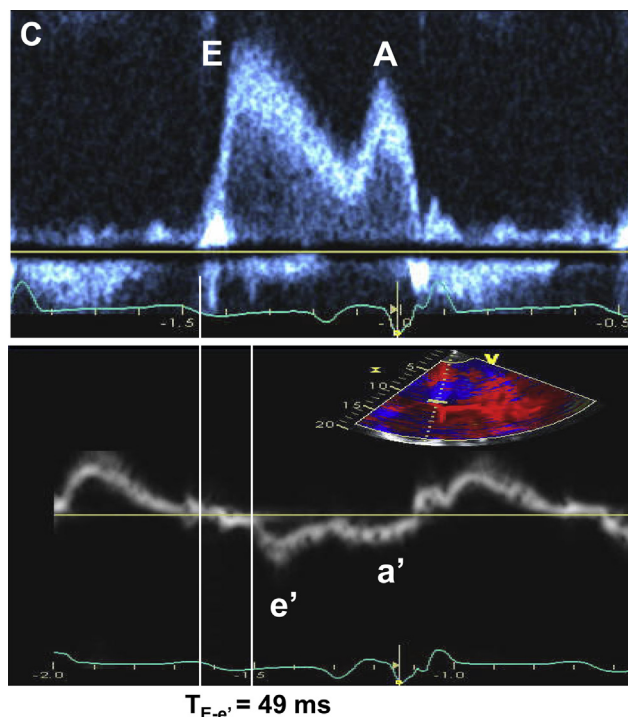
Patient with mitral stenosis and LV diastolic dysfunction. (A) Color Doppler flow across stenotic mitral valve showing flow acceleration zone (*left*) and CW Doppler (*right*) of forward diastolic mitral inflow showing increased peak velocity (1.5 m/sec) and gradient (peak gradient = 8 mm Hg and mean gradient = 3.4 mm Hg) across the stenotic mitral valve. (B) TR jet by CW Doppler (*left*) showing RV-to-right atrial pressure gradient of 49 mm Hg. Hepatic venous flow (*right*) shows forward flow only in diastole (*D*) consistent with increased right atrial pressure. Together, there is evidence of pulmonary hypertension.
